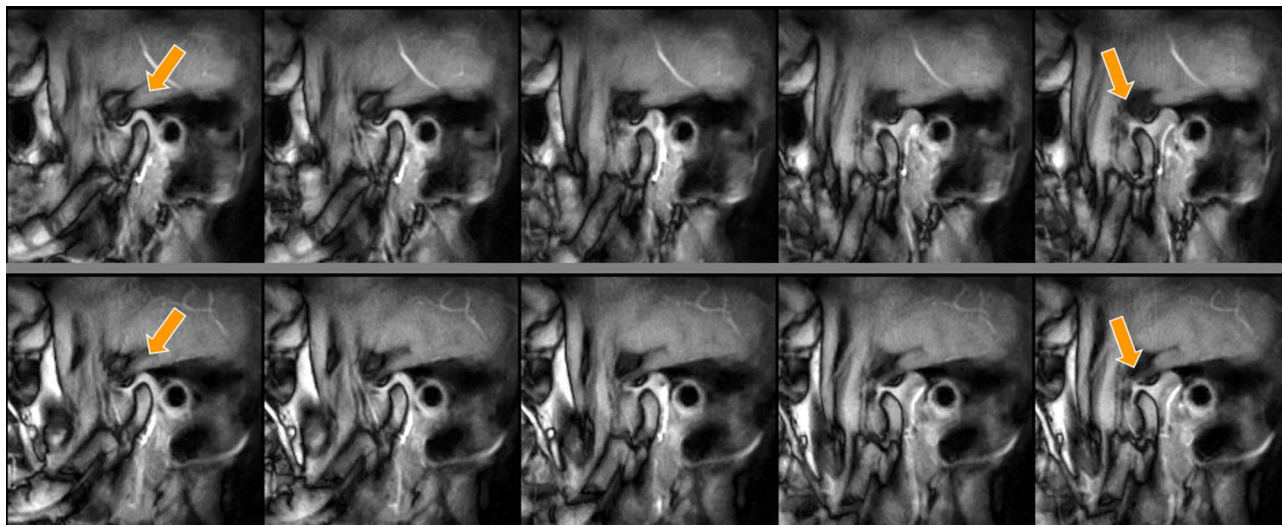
Temporomandibular joint. Selected frames (oblique sagittal views) of 2 simultaneous real-time MRI movies of the (top) right and (bottom) left temporomandibular joint during a single voluntary opening of the mouth (2×50 milliseconds acquisition time, 0.75 mm resolution, 6 mm slice thickness). The frames are 14 images apart (2.4 seconds) and cover the movement of the mandibular disk (bright structure, arrows) from a closed (left) to an open position (right).
